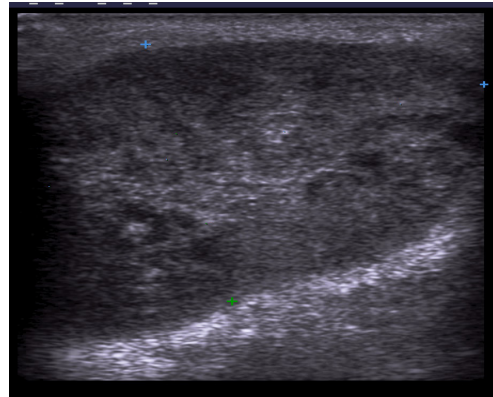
Grey-scale sonography shows an enlarged lymph node on the neck in adenocarcinoma of parotid salivary gland (findings confirmed by PH analysis)
